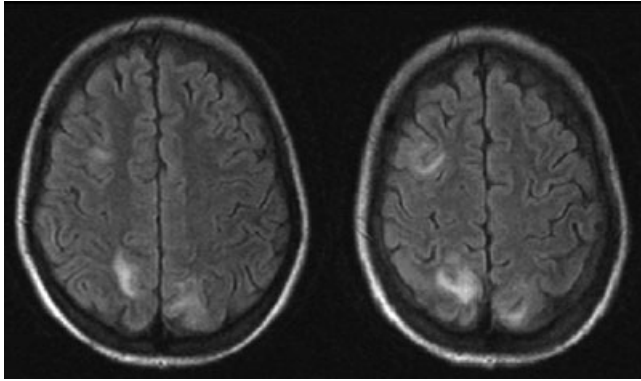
Brain MRI FLAIR showing an increase of signal in both occipital lobes and in right frontal lobe.
